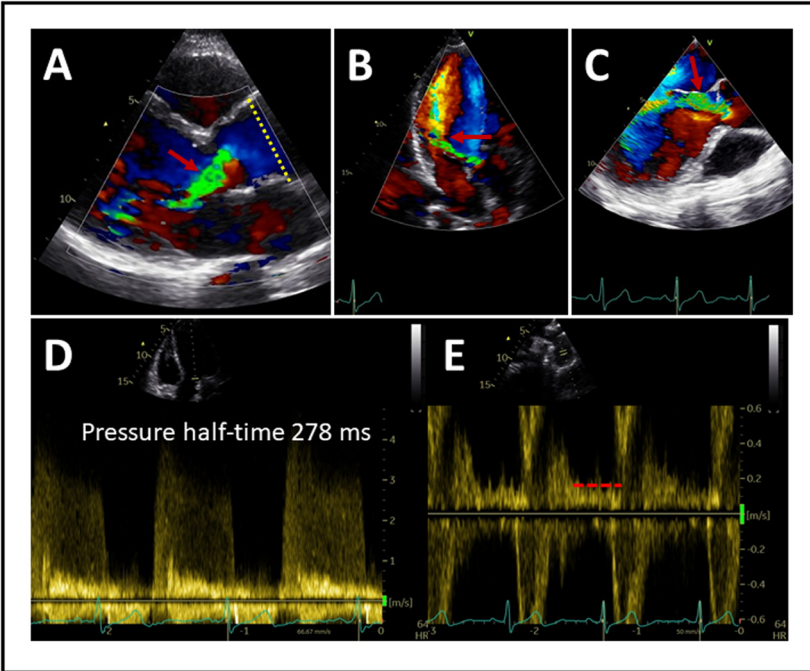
Echocardiographic images of a female patient in her late 30s with newly diagnosed severe aortic regurgitation. No diastolic murmur on heart auscultation was noted by the referral cardiologist. A repeated careful auscultation at Heart Valve Clinic did not reveal any murmur either. A demonstrates parasternal long-axis and B apical 3 chamber views on transthoracic echocardiography, and C is long-axis view on transesophageal echocardiography showing large aortic regurgitant jet (A-C), dilated ascending aorta (A, dotted line) with a tricuspid aortic valve. Pressure half-time was 278 ms (D), and there was a holo-diastolic flow reversal with end-diastolic velocity of 0.2 m/s (E, dotted line). Regurgitant volume was 55 ml, regurgitant fraction 50% and left ventricular ejection fraction of 56% (data not shown).
